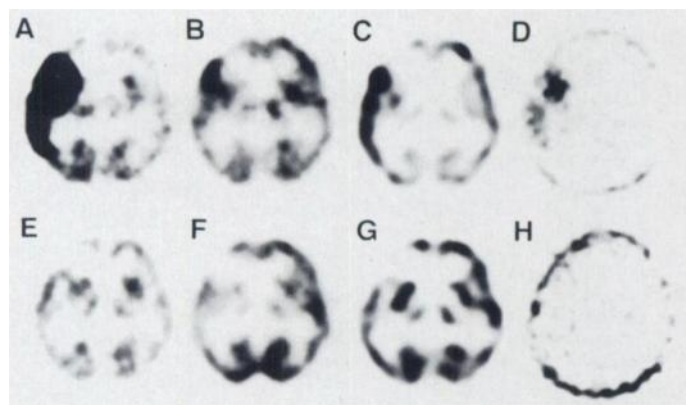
Preoperative examinations demonstrate high uptake of MET (A), FDG (B), HMPAO (C) and Tl (D) in the right frontal lobe. In all examinations, the most intense uptake is observed at the area just posterior to the surgical defect. Postoperative examinations, 2 mo after surgery, demonstrate a new surgical defect in the right frontal lobe without any abnormally high uptake by MET-PET (E), FDG-PET (F) or HMPAO-SPECT (G). Tl-SPECT demonstrates no abnormal uptake (H).
